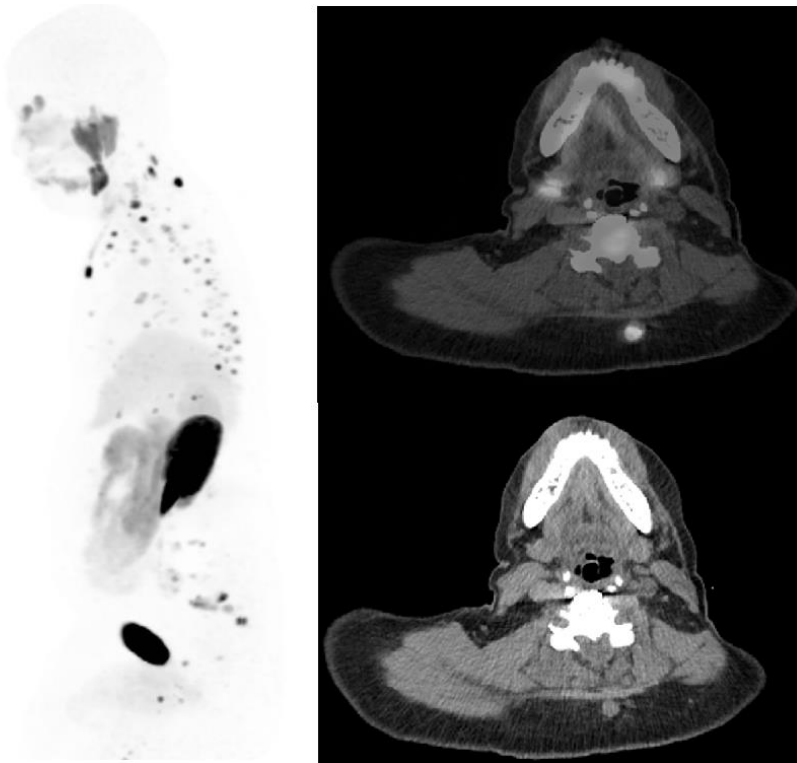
A 58-year-old man with metastatic castrate-resistant prostate cancer diagnosed in 2018 on docetaxel and androgen deprivation therapy. Serum PSA at the time of PET/CT: 79.87 ng/mL. Ga68-PSMA PET/CT: Sagittal MIP images demonstrate extensive uptake throughout the axial skeleton, most consistent with osseous metastases. Axial CT and PET/CT fused images demonstrate focal uptake in a soft tissue nodule posterior to the C6 vertebral body within the subcutaneous fat. A CT-guided biopsy confirmed metastatic prostatic adenocarcinoma at this site.
